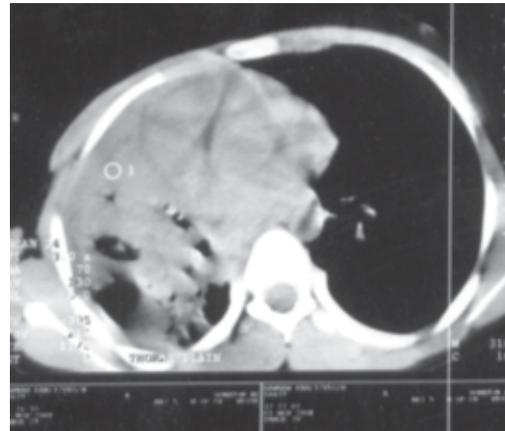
CT scan of lung showing collapse of right lobe.
